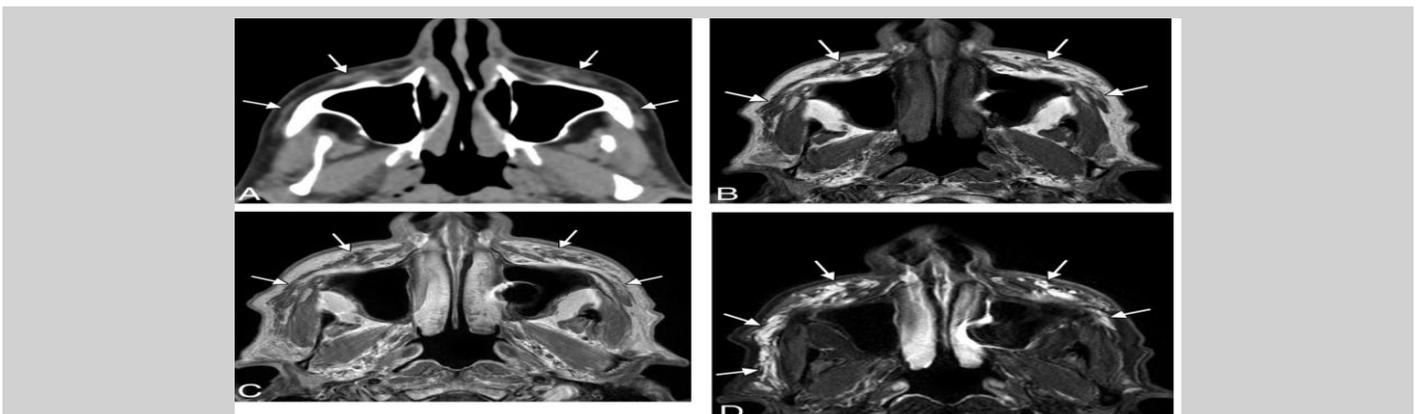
Axial CT image (A) shows filamentous formations within the subcutaneous tissues of both cheeks (arrows). Axial MR images in T1 (B), post-contrast T1 (C), and fat-saturated T2 (D) sequences demonstrate that the filler exhibits signal characteristics nearly identical to fluid (arrows).
